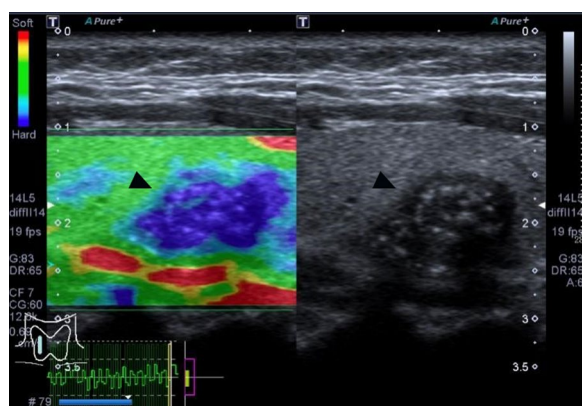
Thyroid nodule showed ES of 5. A 43-year-old female came to hospital for a follow-up visit of thyroid. Ultrasound image showed the entire nodule of papillary thyroid carcinoma and its surrounding area were in blue was consistent with ES of 5 (marked with a black triangle). ES=elasticity score
